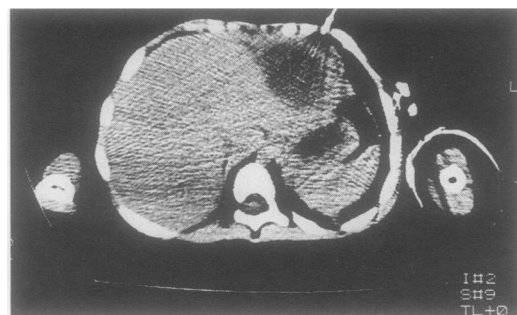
Computed tomogram showing single cavity in the left lobe of the liver.
